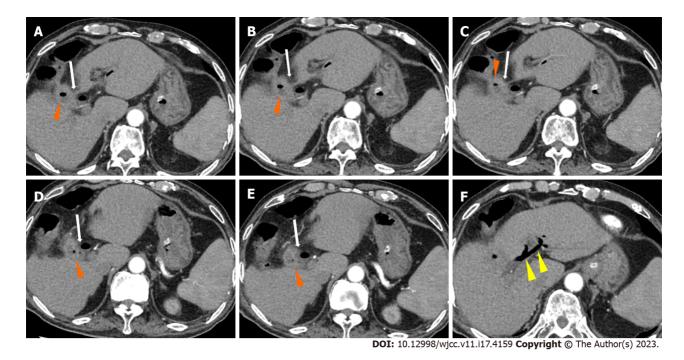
Abdominal contrast enhanced computed tomography (axial view). A-E: Abdominal contrast computed tomography showed pneumatosis in the gallbladder (orange arrows), and the gallbladder communicated with the duodenal bulb (white arrows), indicating cholecystoduodenal fistula; F: Abdominal contrast computed tomography showed pneumobilia (yellow arrows).
